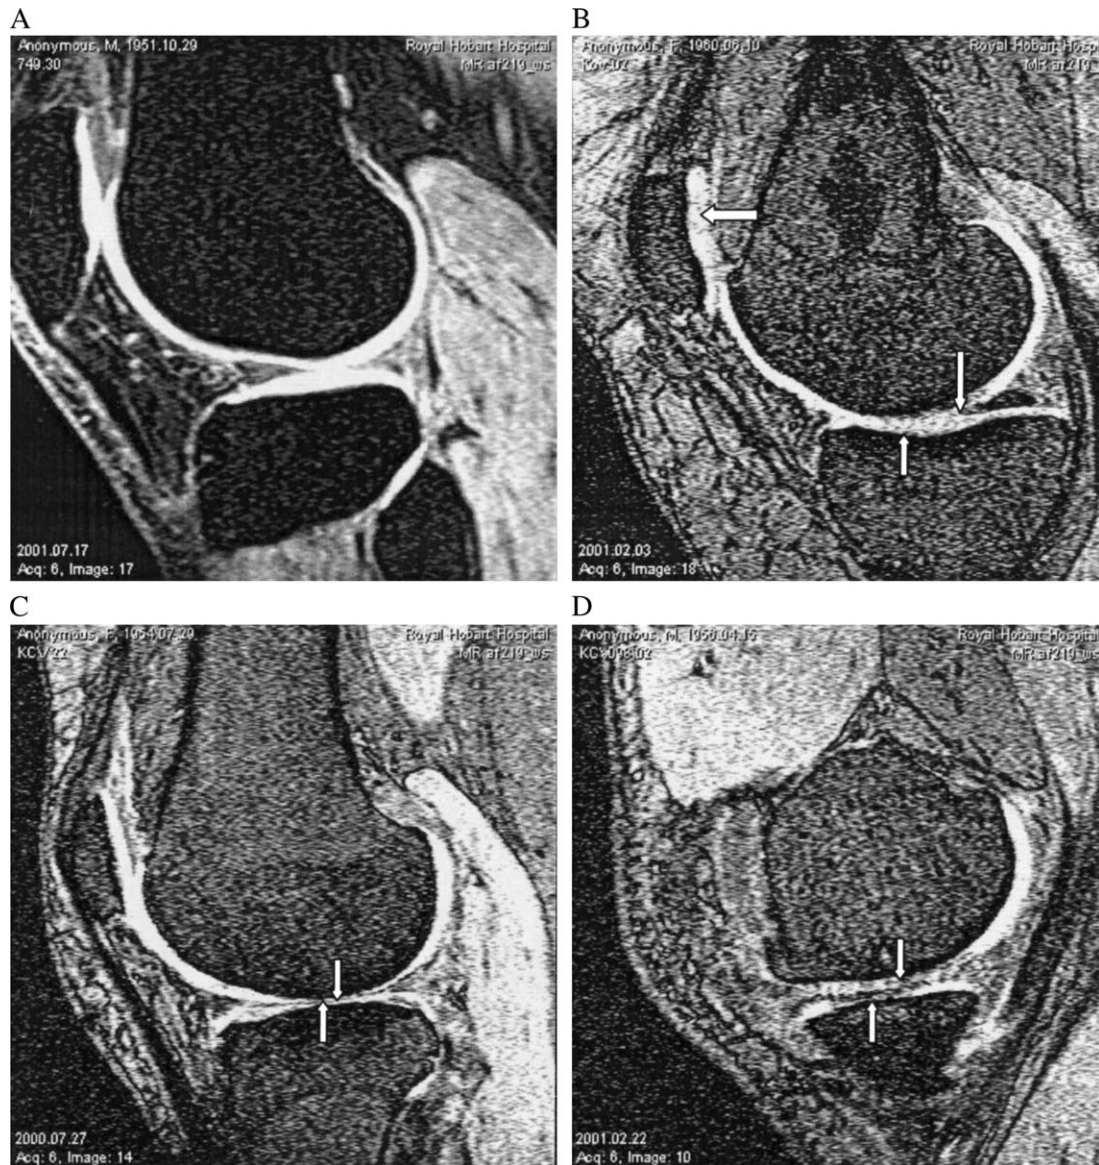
Sagittal T1-weighted fat saturated 3D MRI images shows: (A) Normal lateral tibial, lateral femoral and patellar cartilage (grade 0). (B) Slight cartilage defects at lateral tibial and patellar site (grade 1) but moderate cartilage defects at lateral femoral site (grade 2). (C) Normal cartilage at patellar site (grade 0) but severe cartilage defects at lateral tibial and femoral sites (grade 3). (D) Severe cartilage defects at medial tibial (grade 4) and femoral (grade 3) sites.
